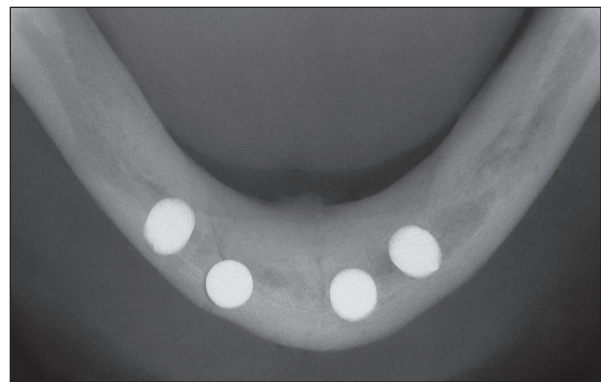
Postoperative occlusal radiograph showing the implant positions; note the lack of mandibular fracture.
